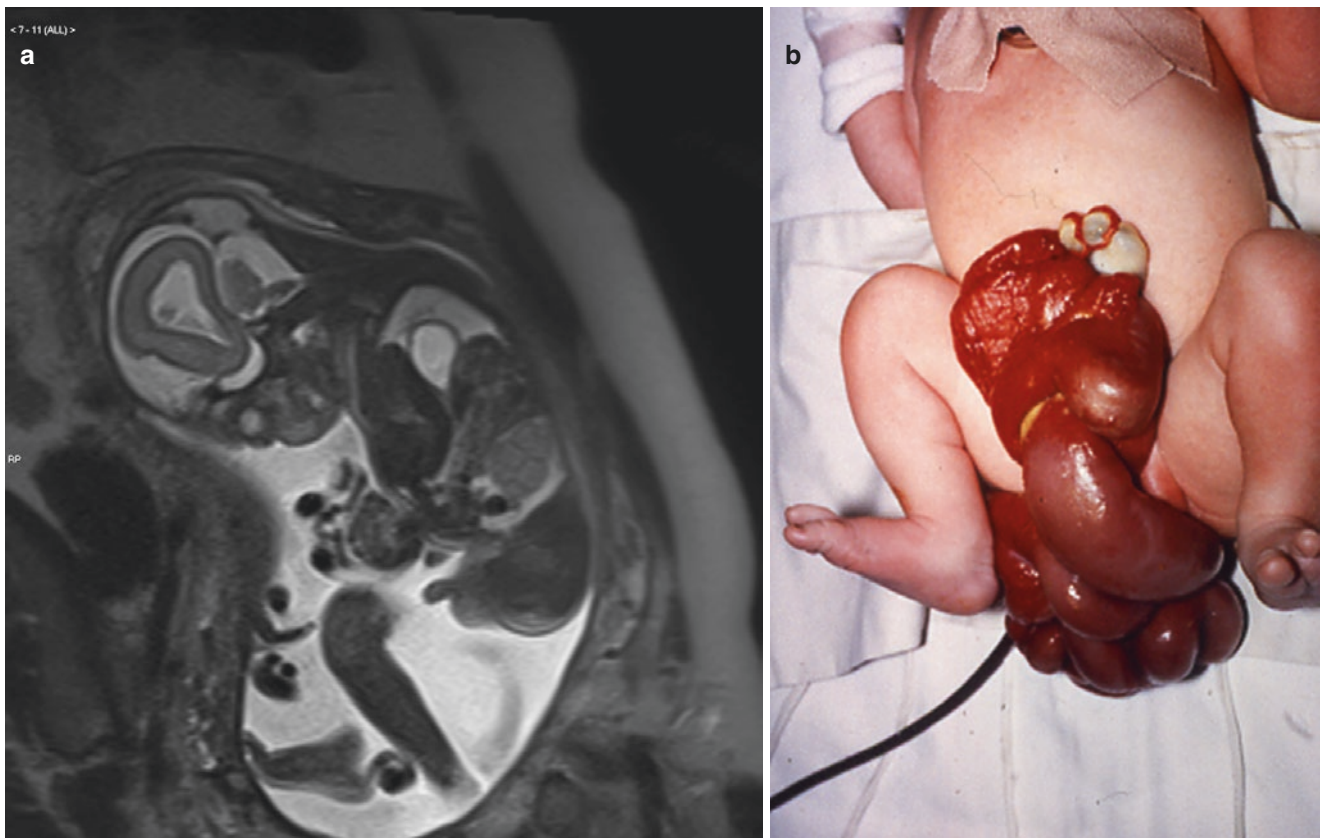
(a) Gastroschisis—Fetal MRI with bowel herniation through anterior abdominal wall defect, very suggestive of a gastroschisis because the individual loops of bowel can be seen floating freely. (b)
